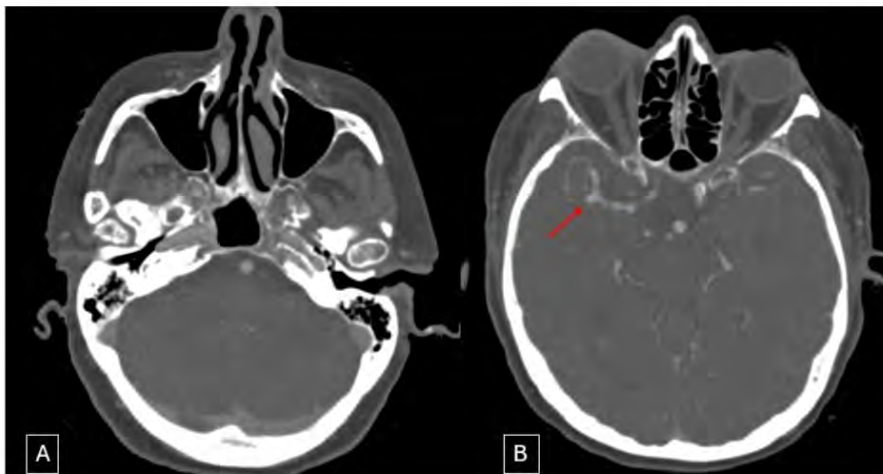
CT Angiogram with a normal intravenous contrast administration was performed using left sided venous access later. Abnormal enhancement has vanished with an early arterial phase study showing contrast predominantly in the intracranial arteries (A, B). Incidentally detected inferiorly directed tiny saccular aneurysm seen at the right M1-M2 MCA bifurcation (B).
